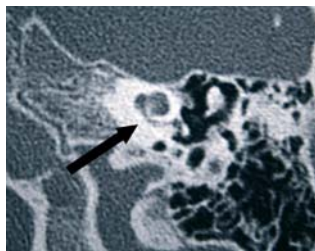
Patient 1; axial CT scan of the left basal cochlea turn with ossification zone (arrow).
